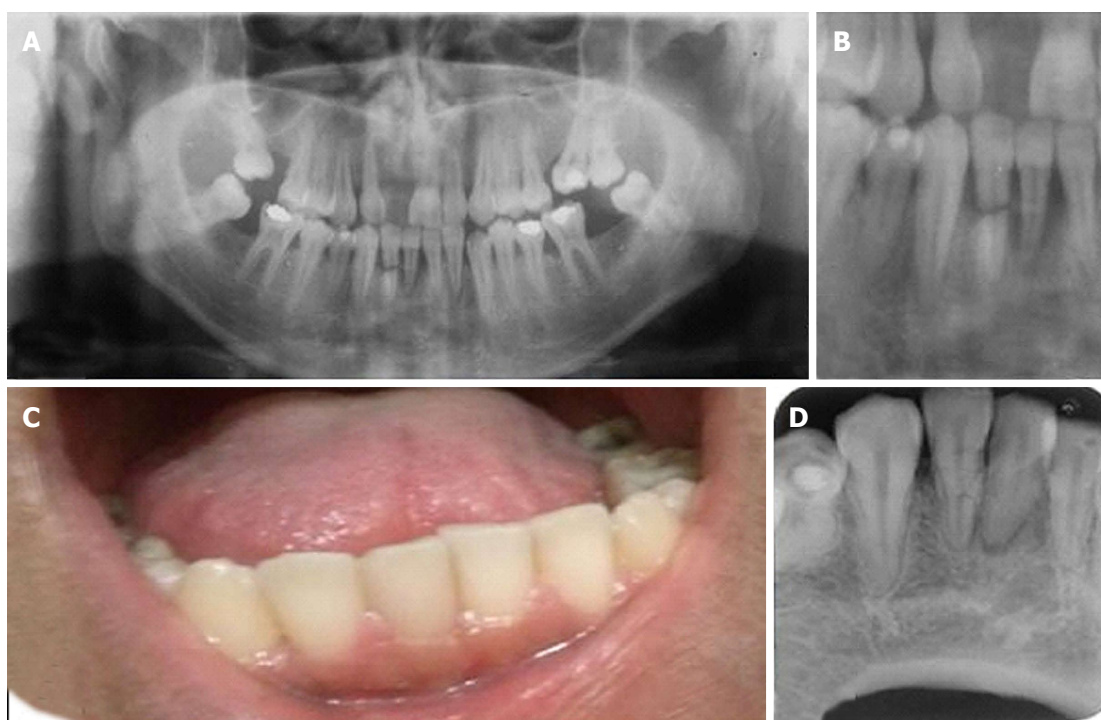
Radiographic and clinical as immobilize the tooth with a semi-rigid splint for 4 wk up to 4 mo. A: Panoramic radiograph taken at the moment of the accident; B: Close at the fractured tooth at the time of the accident; C: Intraoral view. Tooth 41 was slightly grayish while tooth 42 had normal color and no mobility was present; D: Periapical radiograph, tooth 41 with a radiolucent lesion compatible with periapical lesion; tooth 42 with a thin radiolucent line at the fractured line.
